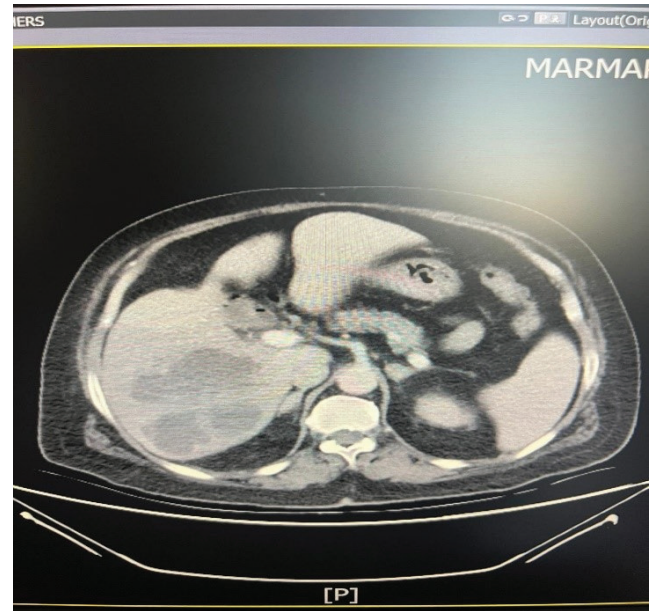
Liver abscess visualized on abdomen CT
